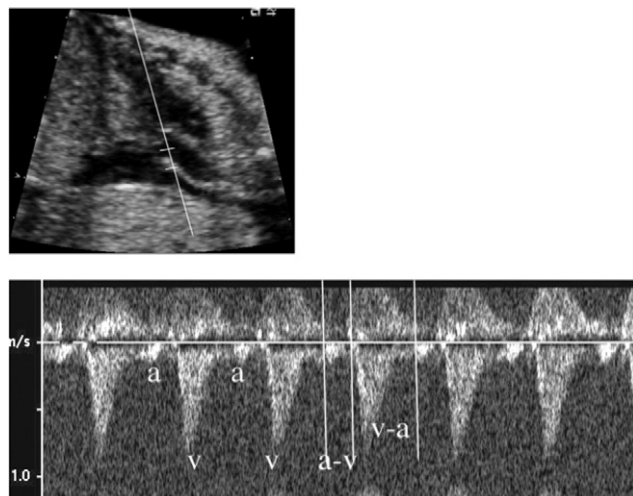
Spectral Doppler ultrasound through SVC and ascending aorta demonstrating long VA interval on fetal echocardiogram.
